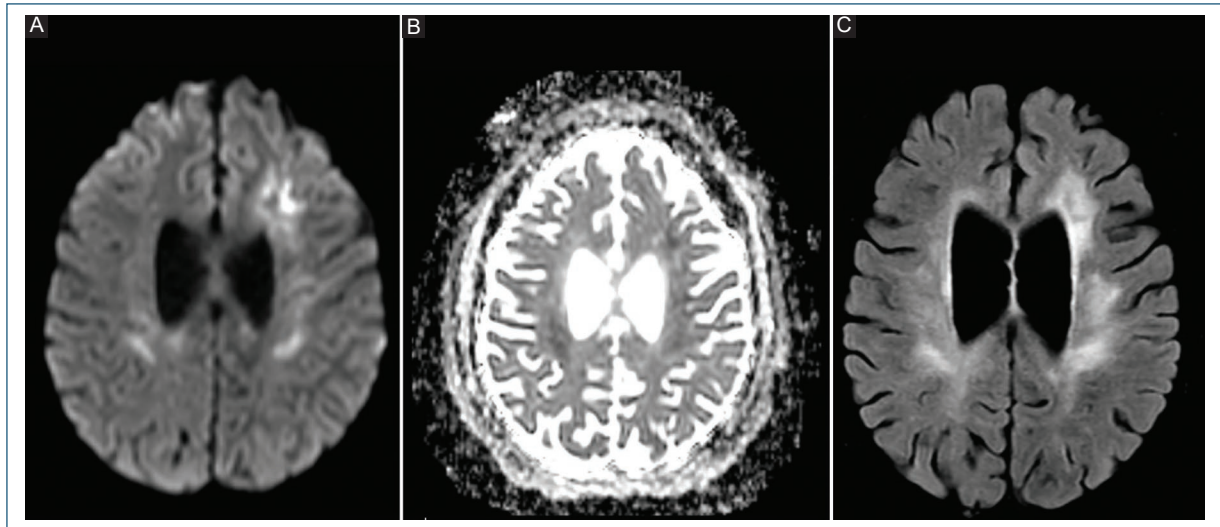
Brain magnetic resonance imaging showing areas of infarction in different acute and chronic stages. A: axial diffusion-weighted imaging (DWI) sequence showing diffusion restriction in the left frontal and right parietal regions. B: axial apparent diffusion coefficient (ADC) image confirming the areas of restriction. C: axial fluid-attenuated inversion recovery (FLAIR) sequence additionally showing old infarcts in the left frontal region.
